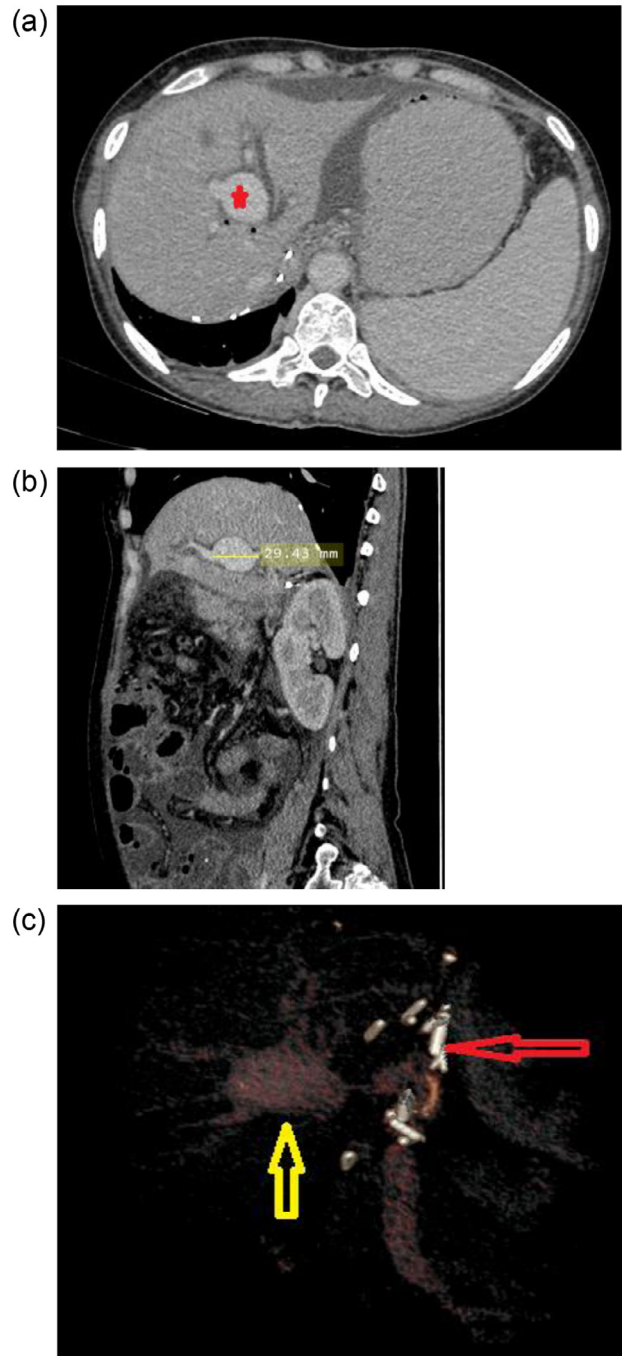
(a) Case 2- Portal venous phase CT abdomen (axial section) depicting an intrahepatic portal venous aneurysm (red star). (b) Case 2- Portal venous phase CT abdomen (Sagittal section) depicting an intrahepatic portal venous aneurysm. (c) Case 2–3 Dimensional VR CT image depicting PVA (yellow arrow) and surgical clips (red arrow).
